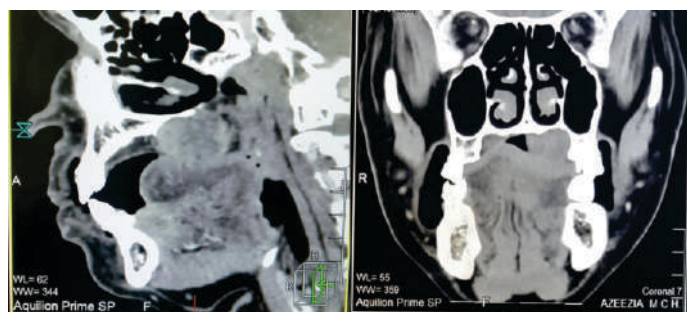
CT showing soft-tissue lesion in the posterior aspect of hard palate on the left side causing bone remodelling of the hard palate
